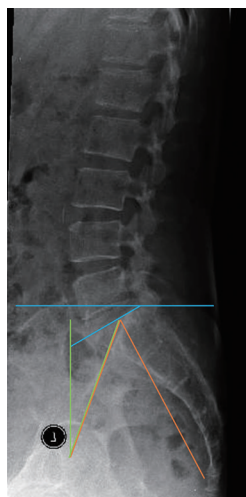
Lumbar spine lateral radiograph measuring pelvic tilt (green line), pelvic incidence (orange line) and sacral slope (blue line).
